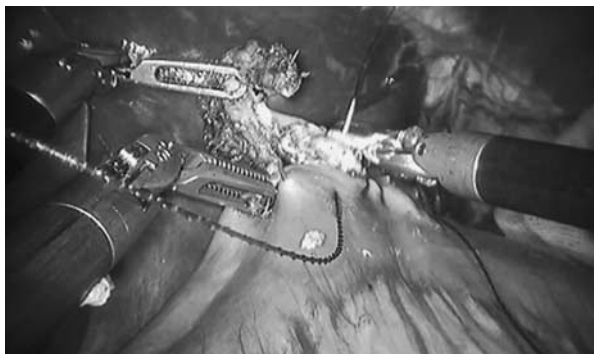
Traction of esophageal stump dissected by an ultrasonic scalpel, with continuous knotless suturing starting between the esophageal wall and jejunal wall.
